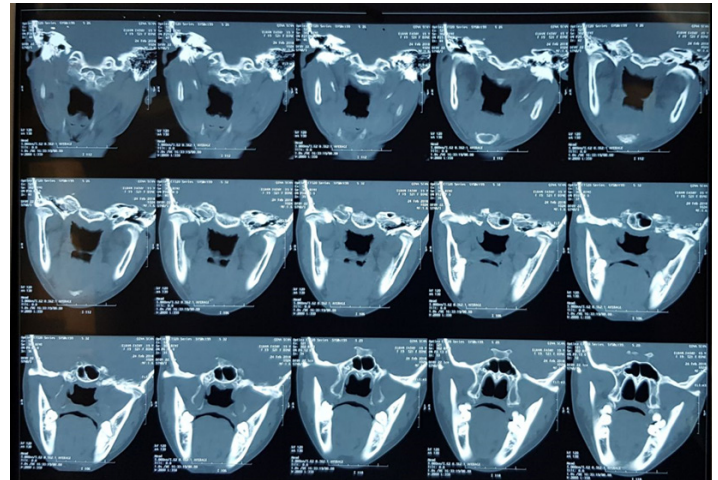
Coronal CT views showing bilaterally deformed condylar heads with reduced joint space and foci of ectopic bone formation in the medial aspect.
